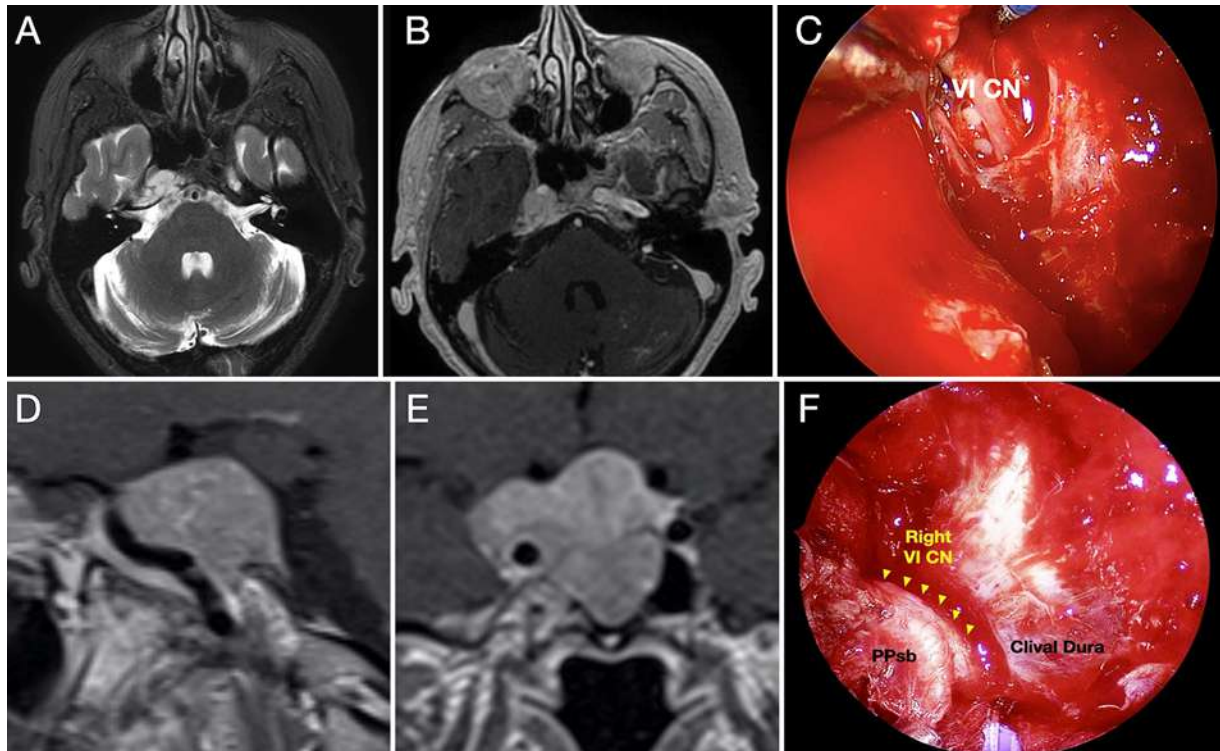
Surgical application. A–C: Case 2. A 74-year-old woman presented with double vision caused by petroclival chondrosarcoma. A: Preoperative axial T2-FLAIR-weighted MR image showing a right petroclival lesion. B: Preoperative axial T1-weighted MR image with gadolinium contrast showing a contrast-enhancing lesion in the right petroclival fissure behind the posterior genu of the ICA. C: Intraoperative view of cranial nerve (CN) VI inside the PVC after drilling the petrosal process of the sphenoid bone (PPsb) and opening the outer dural layer and petroclival dural fold. D–F: Case 3. A 31-year-old woman presented with progressive vision loss and clinical stigmata of acromegaly with elevated growth hormone with CS invasion. D: Preoperative coronal T1-weighted MR image with gadolinium contrast showing a macroadenoma with invasion into the right CS. E: Preoperative sagittal T1-weighted MR image delineating significant invasion into the superior and posterior compartments of the CS with tumor extension behind the posterior genu of the ICA near the right CN VI. F: Intraoperative endoscopic view of CN VI coursing over the petrosal process, which is now covered with a sleeve of dura mater reflected over the bony process. With permission from Juan C. Fernandez-Miranda. Figure is available in color online only.
